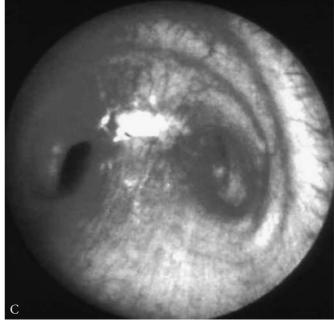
Massive mediastinal fibrosis in a 57-year-old man who had reached an extreme of incapacitating dyspnea. Prior thoracotomy had failed and bronchial dilation proved impossible. A, Detail of chest roentgenogram showing critical stenosis of the right main bronchus (right arrow) and bronchus intermedius plus severe stenosis of the left main bronchus (left arrow). B, Computed tomography scan demonstrating a fibrocalcific mass at the carina in the same patient. C, Bronchoscopy reveals near total obstruction of the right main bronchus and a tiny opening on the left.
